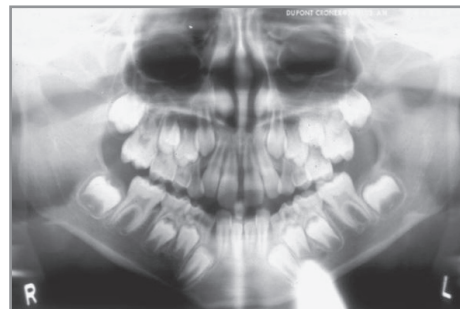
Panoramic radiograph shows impaction of tooth #14.
